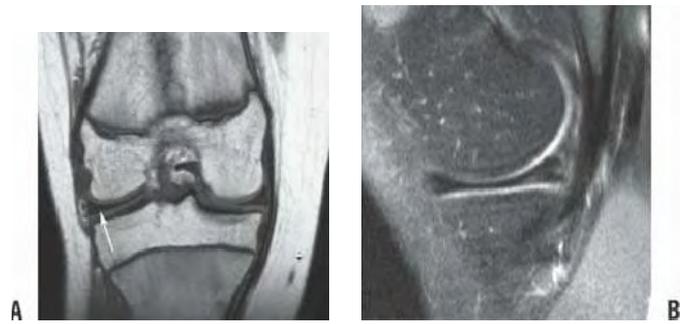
A: T1 weighted coronal image of a discoid lateral meniscus (white arrow) occupying the entire lateral tibial plateau. B: T2-weighted sagittal image showing continuity between the anterior and posterior horns (bow-tie sign).
